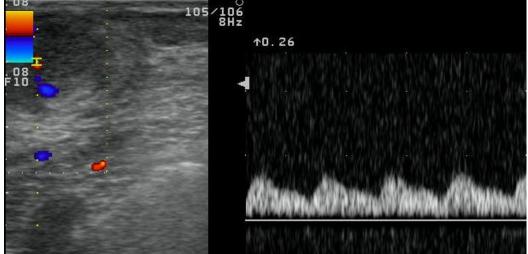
Fibroadenoma with vascularity in 30 yr old patient. The Doppler spectral waveform of the vessels in the mass has the following indices –PI: 0.96; RI: 0.639; PSV: 7 cm/s; EDV: 2.5 cm/s. This benign mass has low PI and low RI.
